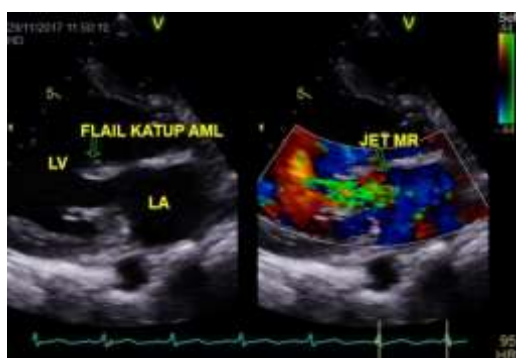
Transthoracic echocardiography (TTE) revealed severe MR due to prolapse of the anterior mitral leaflet (AML)
